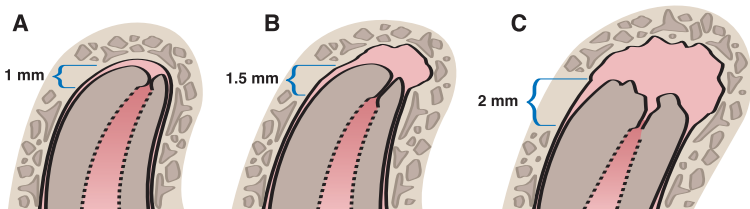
Weine's recommendation for determining working length based on radiographic evidence of root/bone resorption. A, If no root or bone resorption is evident, the preparation should terminate 1.0 mm from the apical foramen. B, If bone resorption is apparent but no root resorption, shorten the length by 1.5 mm. C, If both root and bone resorption are apparent, shorten the length by 2.0 mm. Courtesy of F. Weine.
